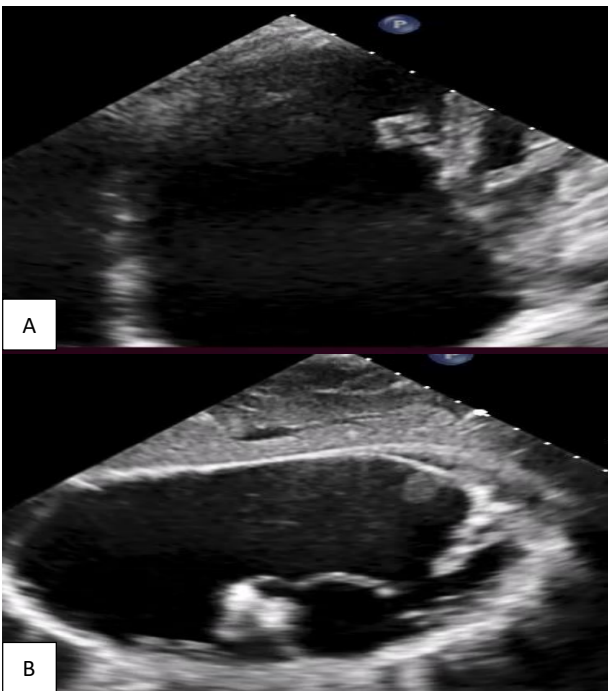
(A and B): 2D echocardiography apical 4 chamber view showing apical displacement of septal tricuspid leaflet. Subcostal view showing septal leaflet in RVOT and tethering of anterior leaflet.
